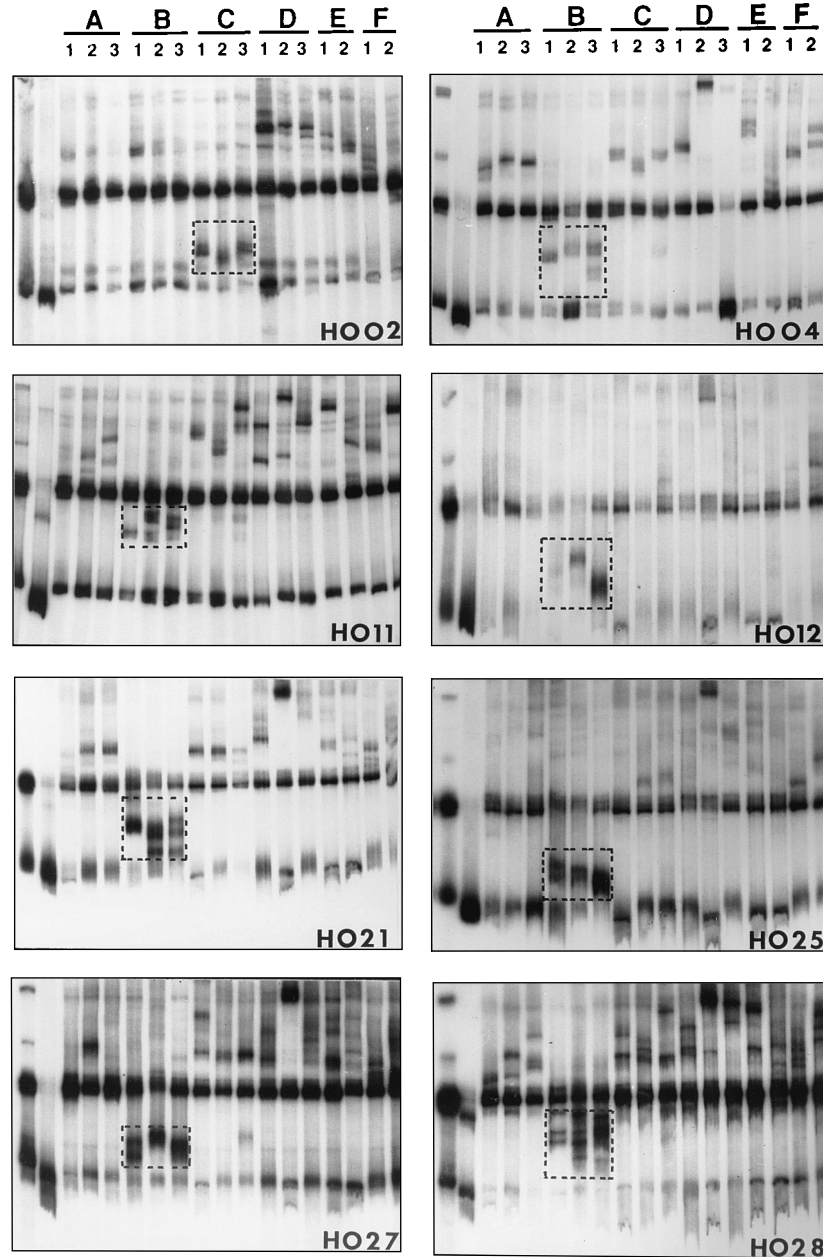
Radiographs of HMA from eight representative patients infected with HIV-1 strains of known subtypes (A through F). The patient's identification number is indicated on the right bottom corner of each gel. The first and second control lanes of each gel are radiolabeled patient DNA in buffer and homoduplex double-stranded DNA formed by thermal denaturation and reannealing of radiolabeled patient DNA and a 100-fold molar excess of unlabeled patient DNA, respectively. The gel migration position of single-stranded DNA is shown in the middle of the first lane, and homoduplex double-stranded DNA is shown at the bottom of both lanes. The remaining 16 lanes of each gel are heteroduplexes formed by thermal denaturation and reannealing of radiolabeled patient DNA and about a 100-fold molar excess of unlabeled known subtype (A through F) reference DNA. The numbers under each subtype represent the reference strains given in parentheses: A (RW20, IC144, and SF170), B (BR20, TH14, and SF162), C (CMA959, ZM18, and IN868), D (UG21, UG38, and UG46), E (TH22 and TH06), and F (BZ162 and BZ163). For example, the bands migrating between the single-stranded DNA and homoduplex double-stranded DNA positions, enclosed by a box, represent the predominant fast-migrating heteroduplexes revealing the genetic similarity of patient HO02 sequence with the three reference strains in subtype C.
